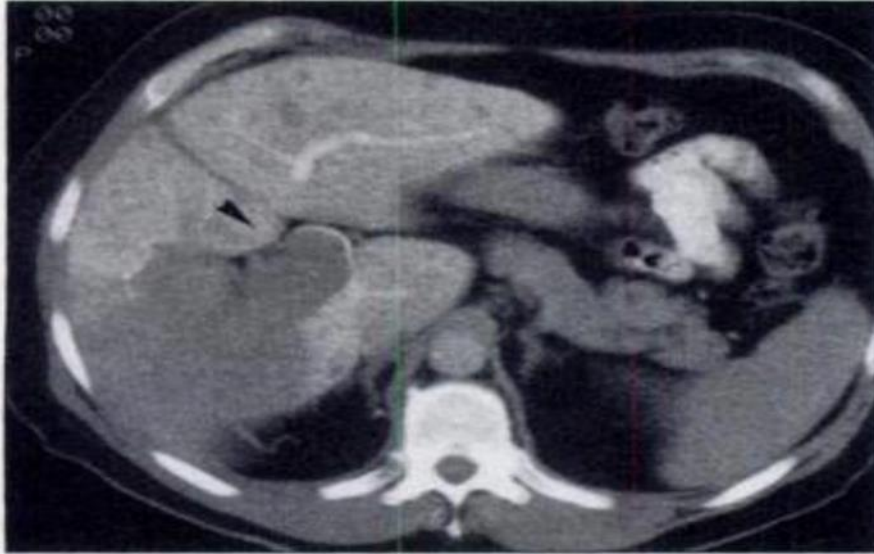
Contrast-enhanced CT scan shows direct extension of hepatocellular carcinoma into right and main portal veins (Malignant portal vein thrombus.). Note marked expansion of portal vein by malignant thrombus (arrowhead) [17].
